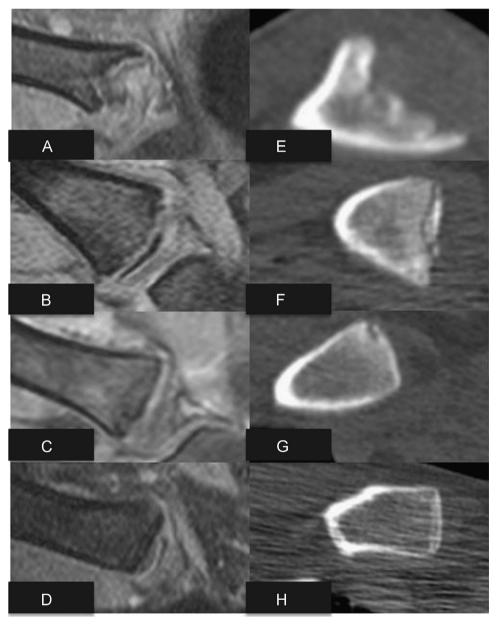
Images representing developmental stages 1–4 of clavicle development as seen in the same individual by MRI (A–D) and CT (E–H). MRI is visualized in the coronal plane, CT in the transversal plane.
